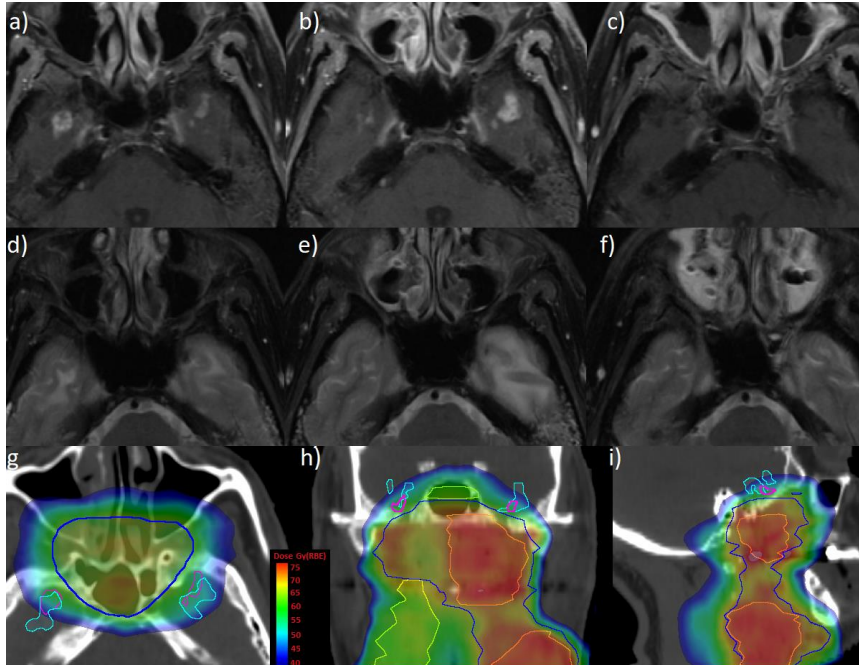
Evolution of RAIC: Male (54 years) with nasopharyngeal cancer, treated with PT and concurrent chemotherapy. 19 months after treatment the patient was diagnosed with bilateral temporal lobe RAIC. The post contrast T1 and T2 weighted MRIs are displayed on top and middle row, respectively. Image a) demonstrates bilateral contrast enhanced temporal lobe lesions on the post contrast T1 weighted MRI, and increased signal intensities on the corresponding T2 sequence (d). b): MRI two months later shows decrease in size on the contrast enhanced lesion in the right temporal lobe and increase in size and enhancement in the left temporal lobe. The area with hyperintensities on the T2 weighted MRIs has correspondingly decreased and increased in volume (e). c) and f): MRI 33 months after diagnosis of RAIC: RAIC lesions have resolved spontaneously without medical intervention. Bottom row: IMPT dose distribution displayed in representative axial (g), coronal (h) sagittal views (i). CTV 1 (70 Gy[RBE]) and CTV 2 (63 Gy[RBE]), CTV 3 (57 Gy[RBE]) shown in orange, blue and yellow, respectively; T1w lesion is contoured in magenta and T2w lesion in cyan.
